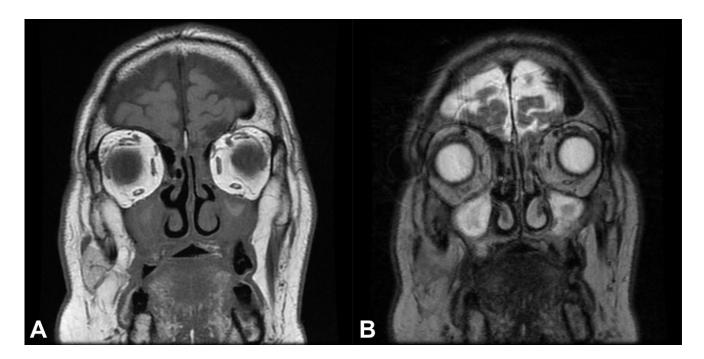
(T1-weighted image) and 5B (T2-weighted image): MRI after treatment revealed T2-hyperintense tissue occuping maxillary sinuses and some ethmoidal cells which had a central component with discrete spontaneous hypersignal at T1; these aspects were compatible with residual inflammatory alterations, neglecting the hypothesis of residual lymphoma. There was also hypointensity on T1-weighted in the alveolar and hard palate arches, without associated masses, which may reflect secondary changes due to the previous tumor presence. No meningeal involvement or tumoral lesion was found in the adjacent intracranial compartment.
